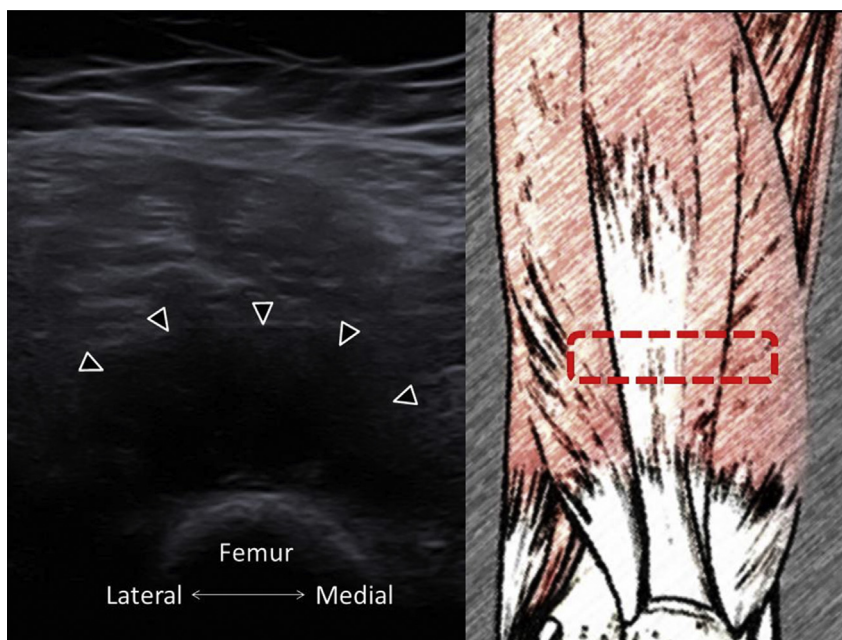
B-mode ultrasound imaging of right distal thigh. The arrowheads indicate the lesion.
